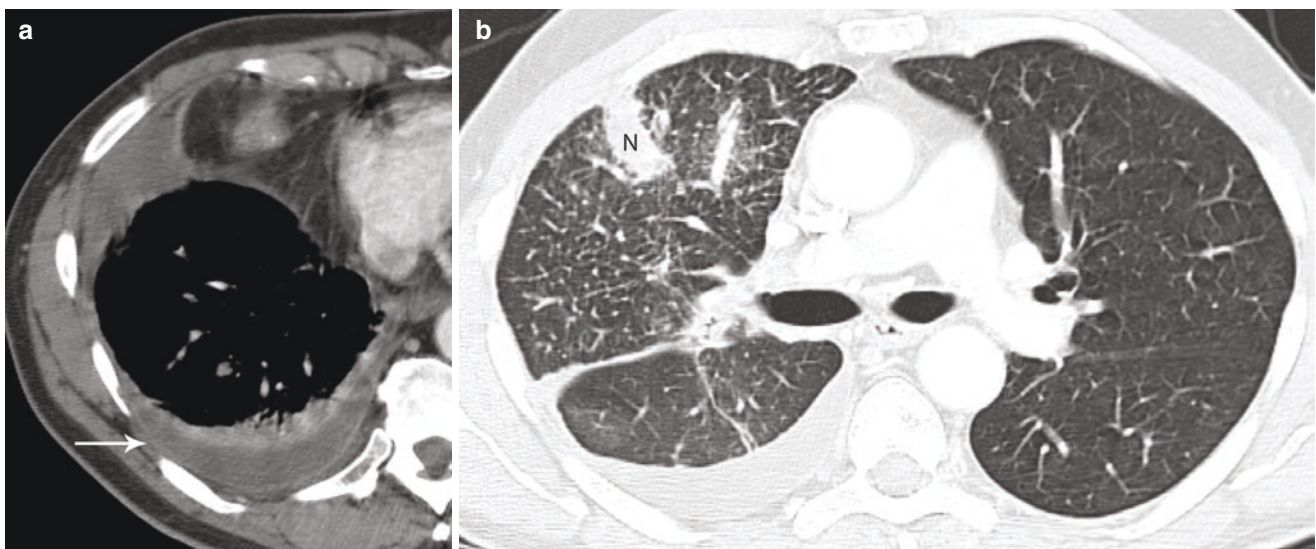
(a) Contrast-enhanced axial CT shows right pleural thickening with a small right pleural effusion; (b) contrast-enhanced axial CT shows interlobular septal thickening and an irregular 2 cm right upper lobe solid nodule (N)
